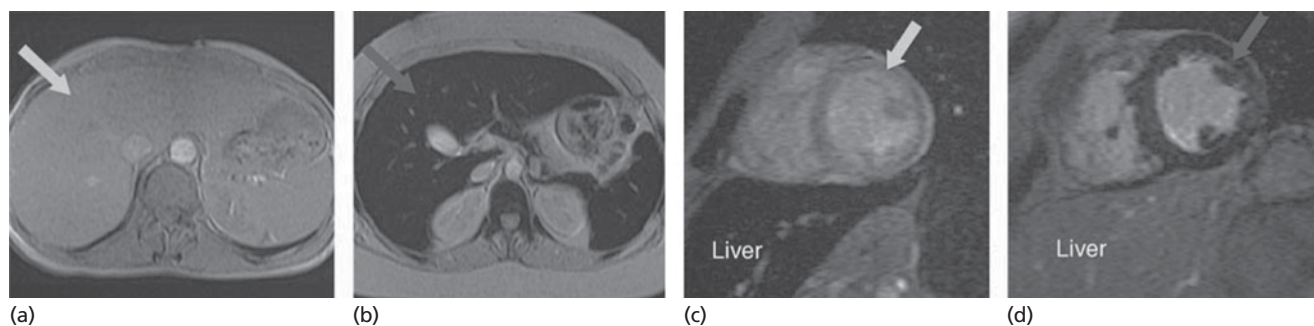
Magnetic resonance imaging T2* technique. Tissue appearances of liver and spleen: (a) normal; (b) tissue iron overload; (c) severe liver iron overload with normal cardiac iron; (d) severe cardiac iron deposition with minimal liver iron
